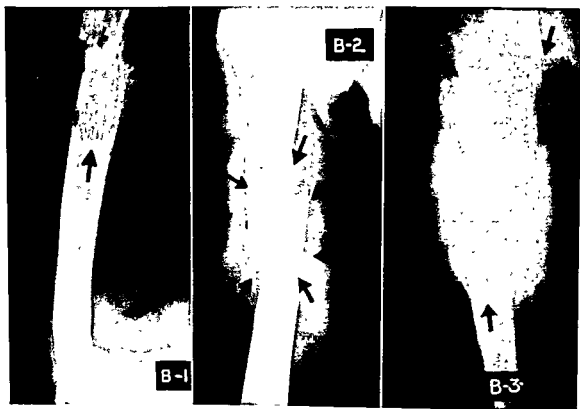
Osteoclastic metastasis in humerus from carcinoma of rectum. Series of radiographs showing progressive rarefaction and destruction of shaft of upper one third of humerus with pathologic fracture and resultant soft-tissue invasion and swelling.
